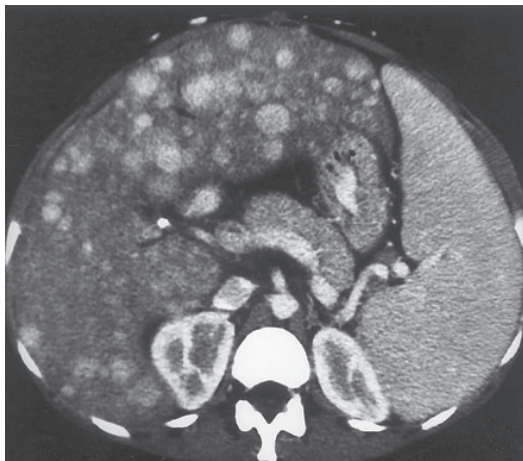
Chronic Budd-Chiari Syndrome in a 42-year-old female with unknown etiologies. Contrast-enhanced CT shows multiple hypervascular regenerating nodules, commonly found in this condition. Splenomegaly is noted secondary to portal hypertension.
